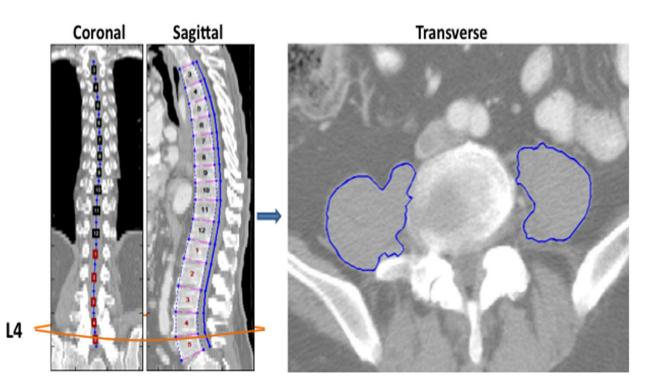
Sagittal and coronal computed tomography (CT) images are used to identify the fourth lumbar (L4) vertebra and adjacent paraspinous muscles.
